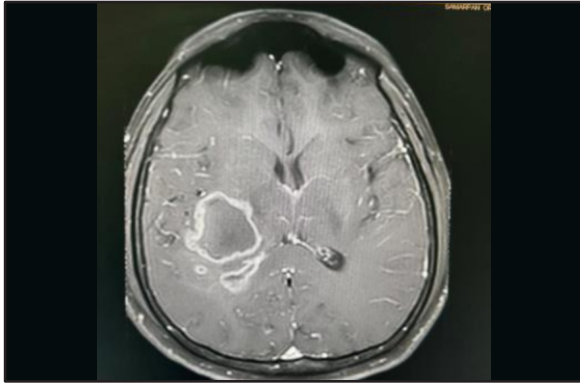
T1W MRI image with contrast enhancing hyperintense lesion
